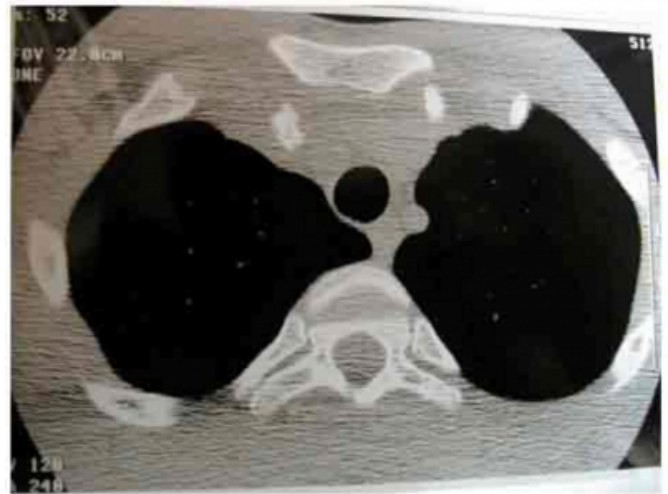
CT scan of the Sternoclavicular Joint revealing the posterior dislocation and the mediastinal oedema
